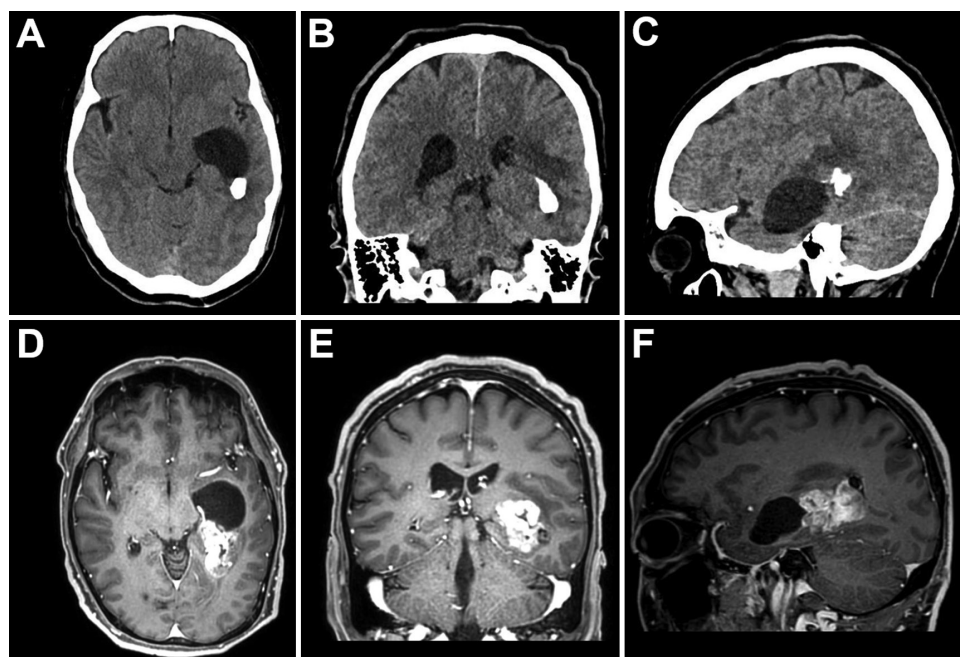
Preoperative image findings. Preoperative axial (A), coronal (B), and sagittal (C) CT scans showing a calcified mass in the left temporal triangular region, leading to localized dilation of the inferior horn of the left lateral ventricle. Preoperative axial (D), coronal (E), and sagittal (F) MR images showing a heterogeneously enhancing lesion with irregular margins and indistinct boundaries, indicative of an infiltrative process.
